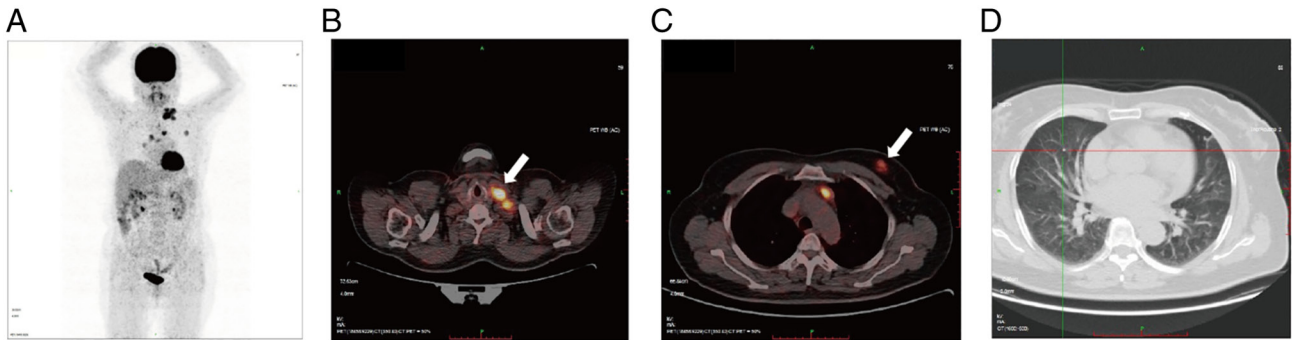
PET-CT images of the patient. (A) Whole-body coronal PET-CT image. (B) FDG uptake (arrow) in the left breast lesion. (C) FDG uptake (arrow) in the left cervical lymph nodes. (D) Small nodule in the right lung without metabolic activity. PET-CT, positron emission tomography-computed tomography; FDG, fluorodeoxyglucose.
